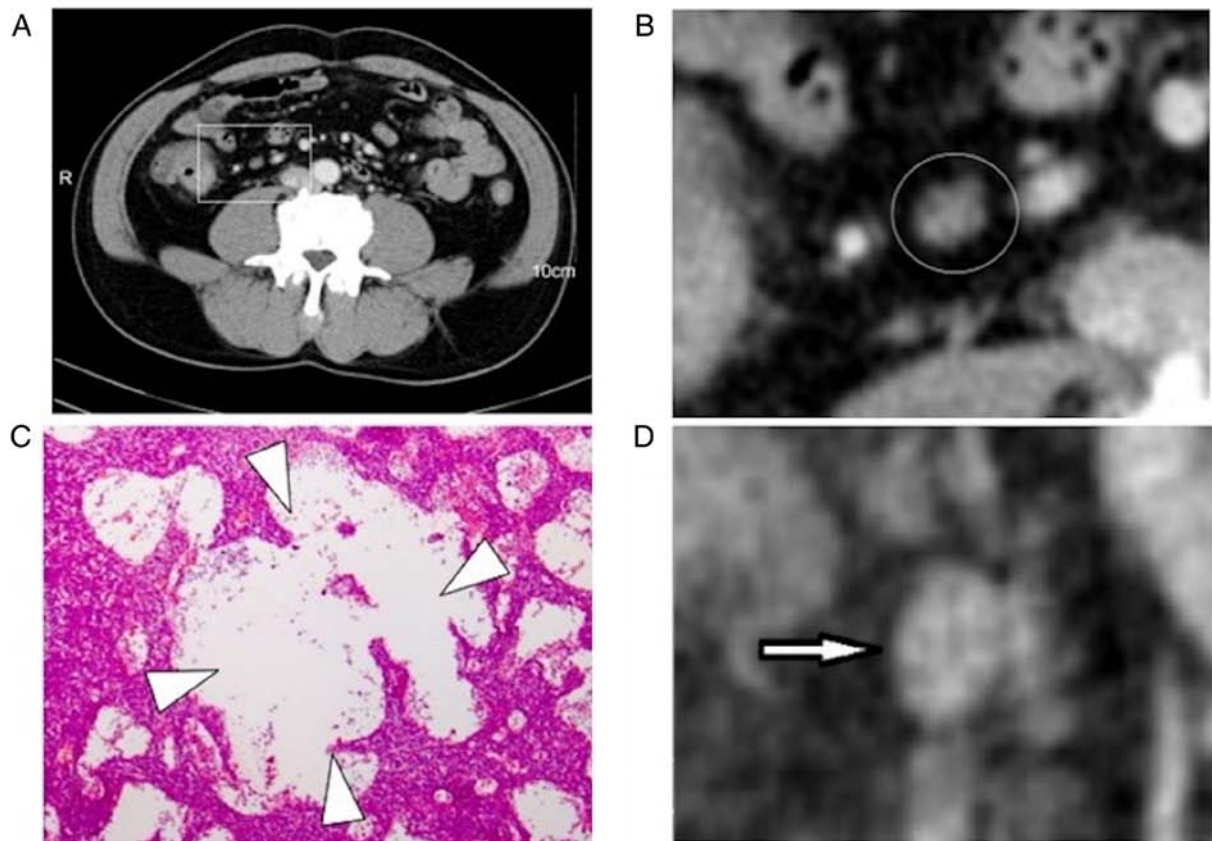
Spotted characteristics (A) Colon cancer in the ascending cancer. (B) Transverse contrast-enhanced CT scan images showing a tumor located in the ascending colon, and a lymph node showing spotted characteristics (magnification 5x). (C) The region of the pathological section indicated with a white arrow, exhibited several dilated subcapsular sinuses (magnification, 100x). (D) An additional lymph node (white arrow) with spotted characteristics.
